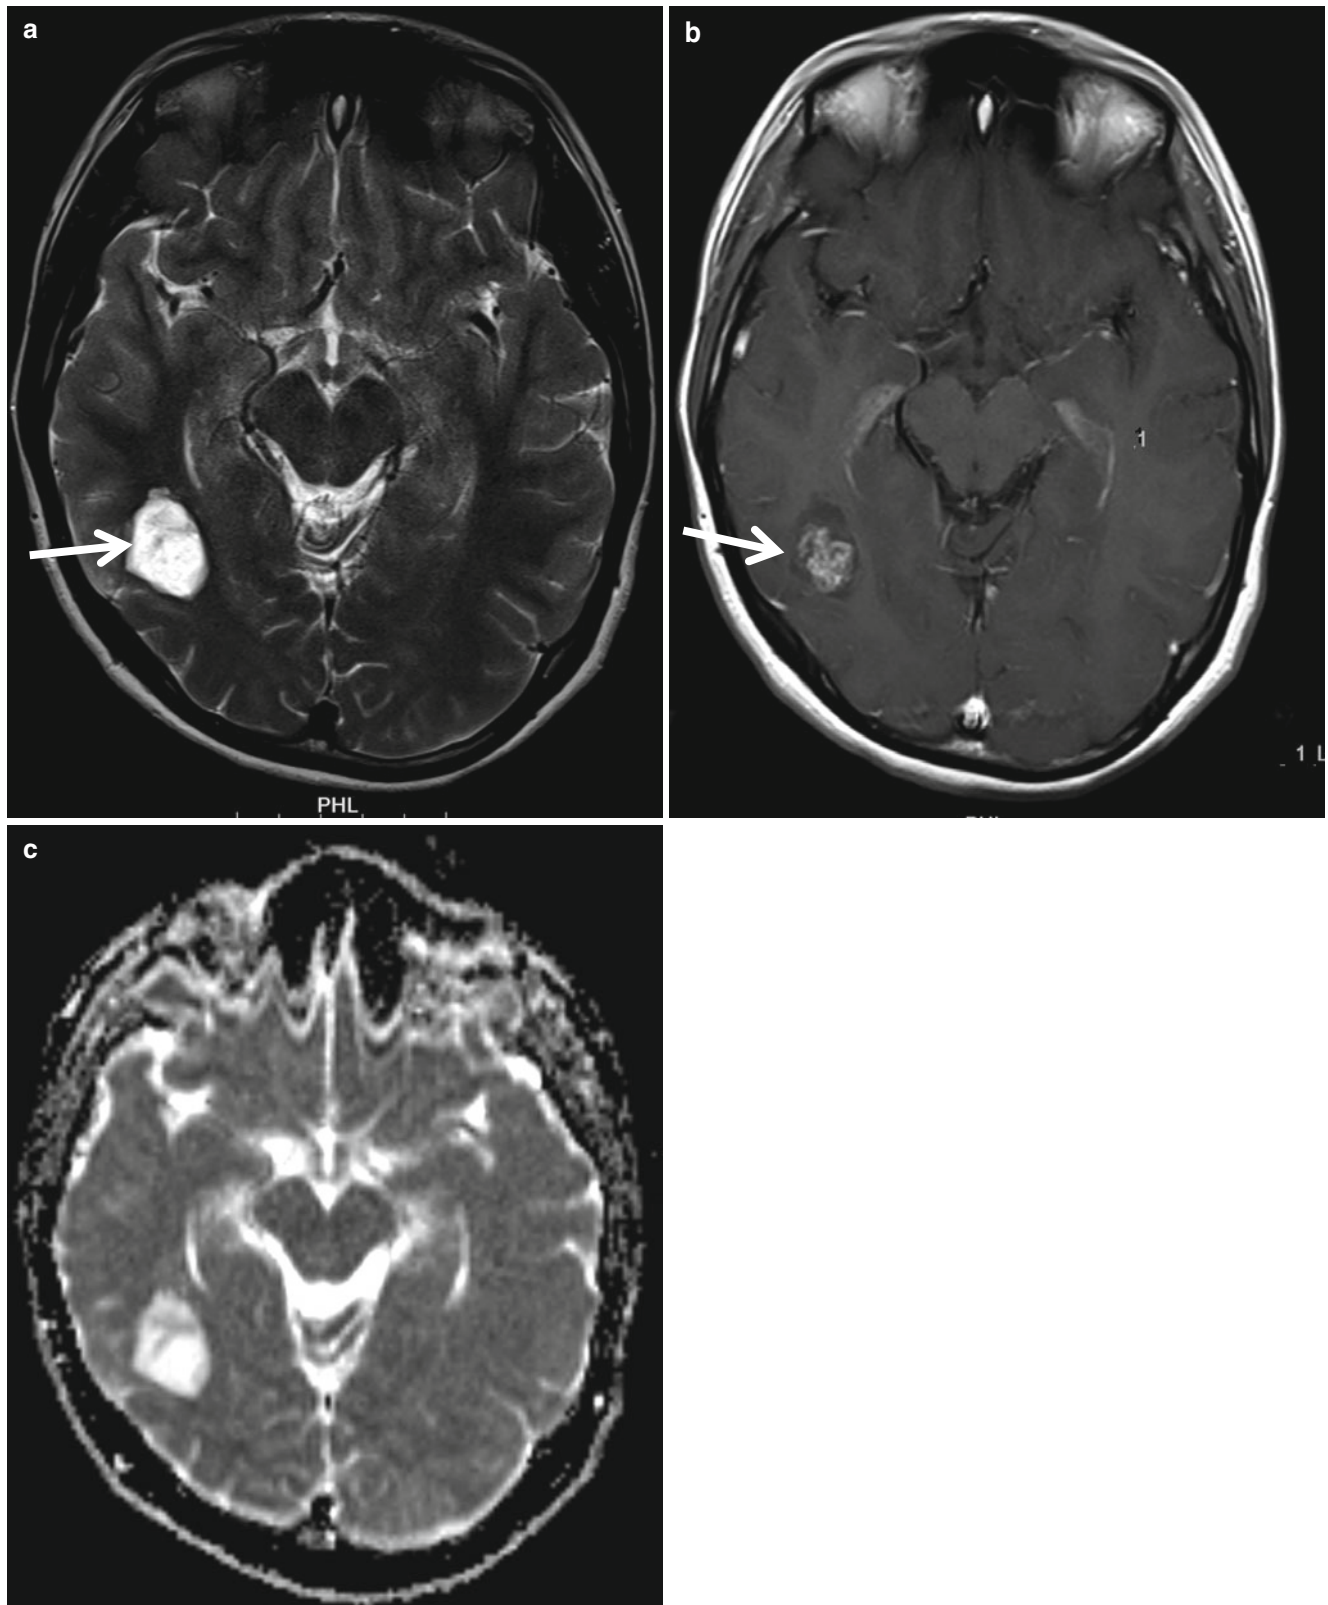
Small hemispheric JPA in a 14-year-old boy. (a) T2-weighted axial image shows well-defined high-intensity mass (*arrow*) in the right temporo-occipital lobe. (b) The mass is heterogeneously enhanced after contrast administration. (c) Increased ADC is seen on water diffusion map
